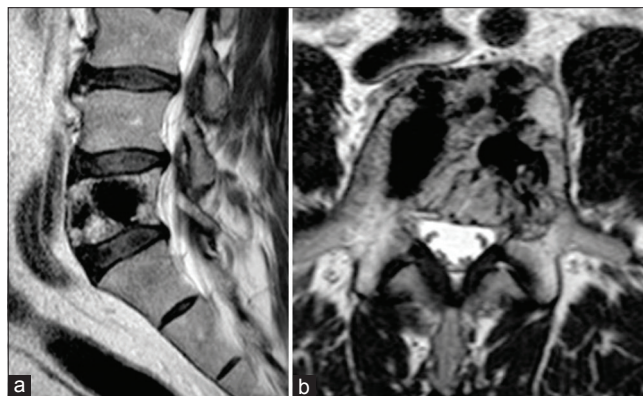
Sagittal (a) and axial (b) lumbosacral T2-weighted magnetic resonance imaging 24 months after the procedure shows no signs of local recurrences
